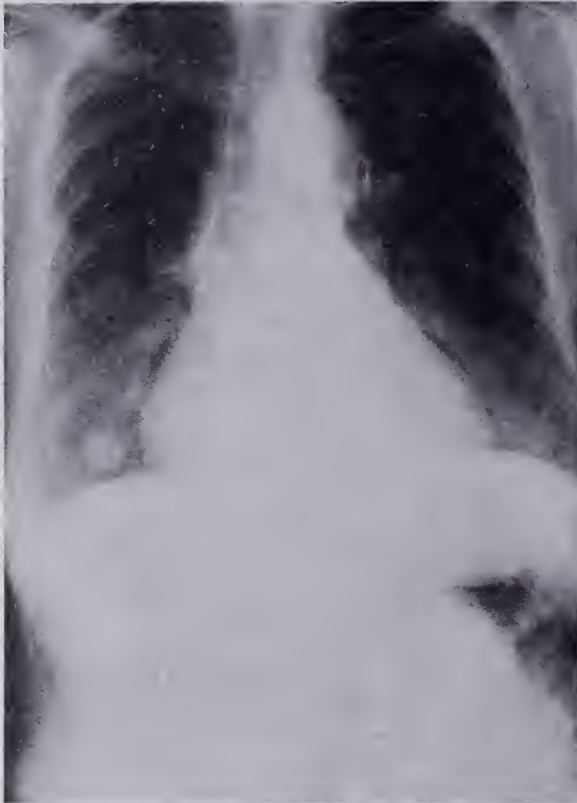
Admission chest x-ray, June 19, 1975, showing nodular lesions in the right lower and left upper lung fields.
